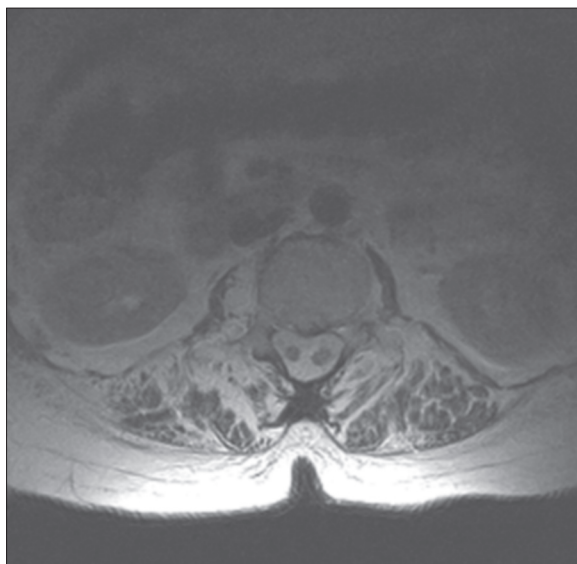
T2-weighted image, axial plane, level L2: a single dural sac containing both hemicords.
